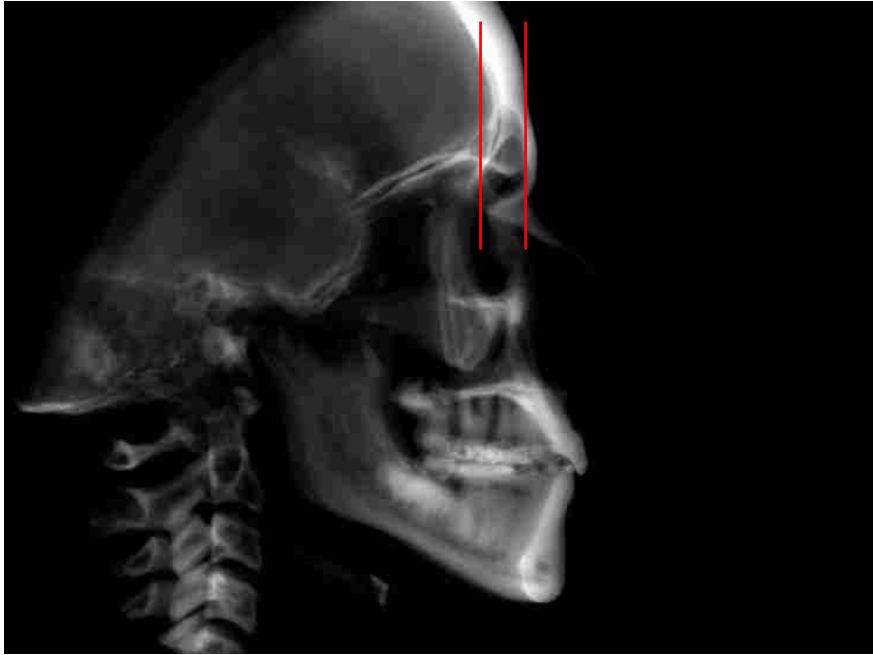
Anterior and posterior borders of the frontal sinus from a sagittal view (Cephalogram derived from CBCT using Invivo 5.3 Software)
